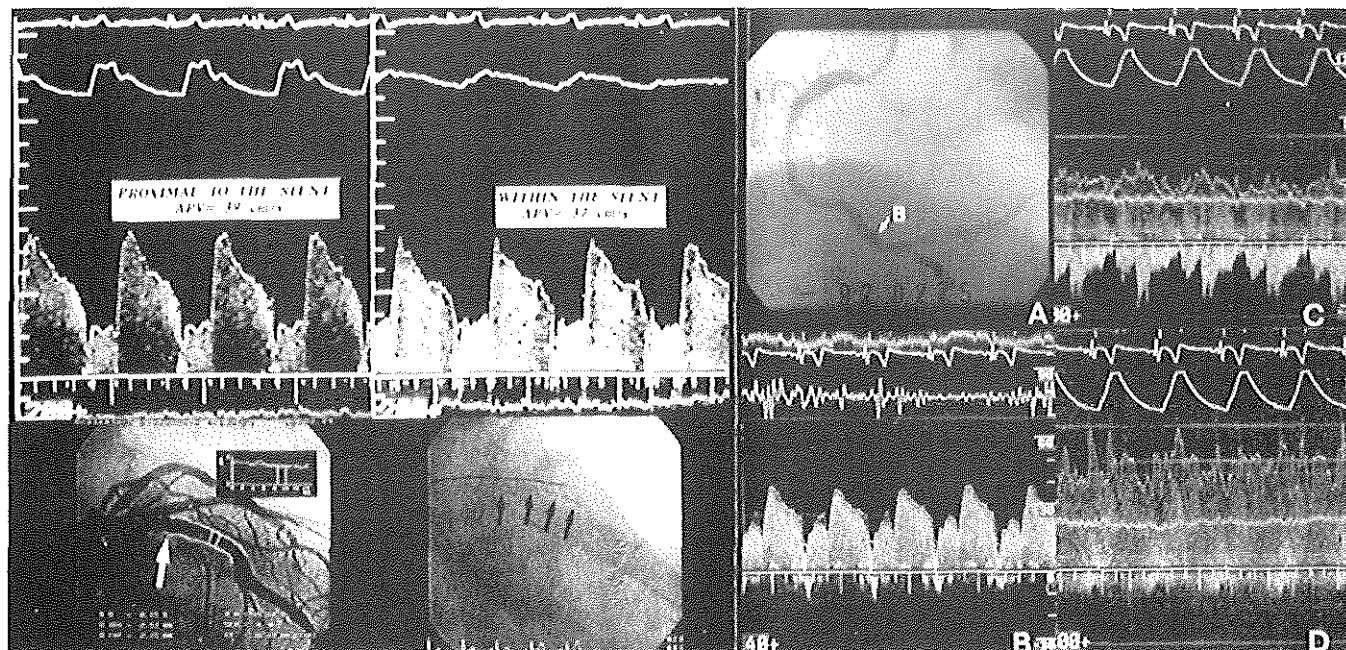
A*, Flow-velocity recordings immediately distal and within a stented coronary segment. Note that the maximal velocity and velocity pattern are unchanged proximal to the stent (*upper left panel*) and within the stent (*upper right panel*). In the lower left panel, an arrow indicates the position of the Doppler sample volume proximal to the stent and two lines indicate the sample volume within the stent. In the fluoroscopic image in the lower right panel, arrows indicate the poorly radiopaque stent. *B*, Flow-velocity recordings distal (*B*) and within (*C,D*) a coronary stenosis after coronary balloon angioplasty: In the right upper panel (*A*) the position of the velocity recordings distal to the stenosis is indicated with an arrow and, more proximally, the tip of the Doppler guidewire is positioned in the segment treated with balloon dilation. Note the marked increase in flow velocity from the distal reference segment (*B*) to the dilated stenosis (*C,D*), with an almost continuous flow and a negative velocity component probably indicating a retrograde filling of the angiographically visible dissection.
